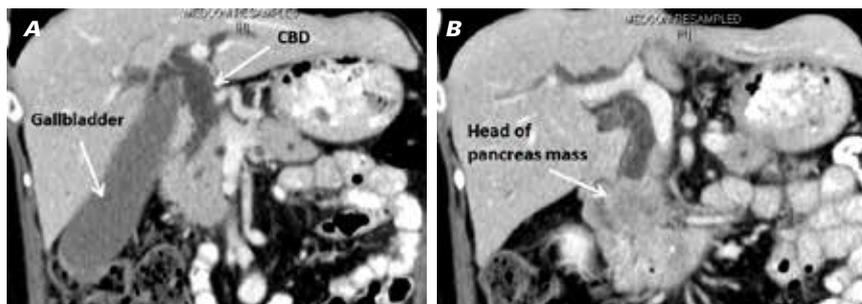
Multidetector CT Abdomen in a 65-year old lady who presented with obstructive jaundice
